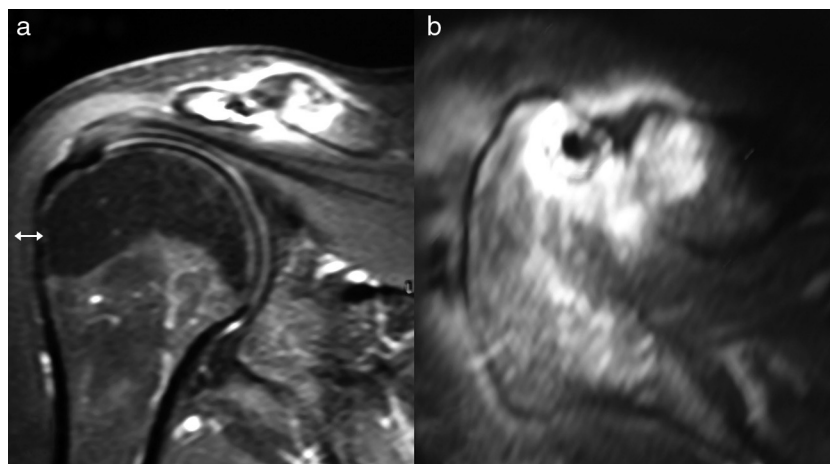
Magnetic resonance images of the right shoulder, coronal (a) and axial (b) section, showing acromioclavicular arthrosis with severe swelling in the joint and a cyst (nidus) into the acromion, next to the joint.
